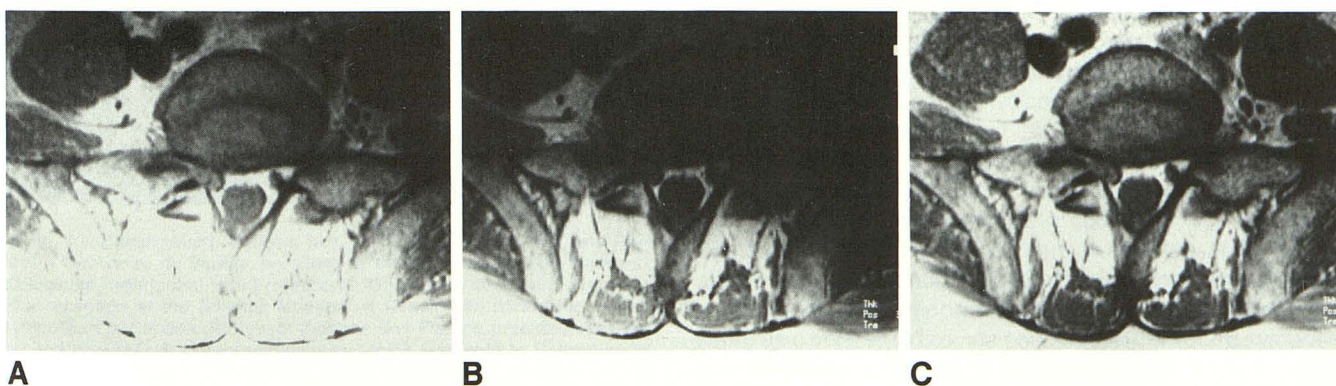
Proton-density-weighted axial MR images before and after normalization using a 12 × 24 cm diameter flat surface coil. A, This image is windowed for visualization of the disk and prevertebral space with high signal obscuring the posterior soft tissues. B, Posterior soft tissues are well delineated but there is marked signal loss in anterior region. C, Normalized image shows equal distribution of signal intensity and good contrast in all regions.
